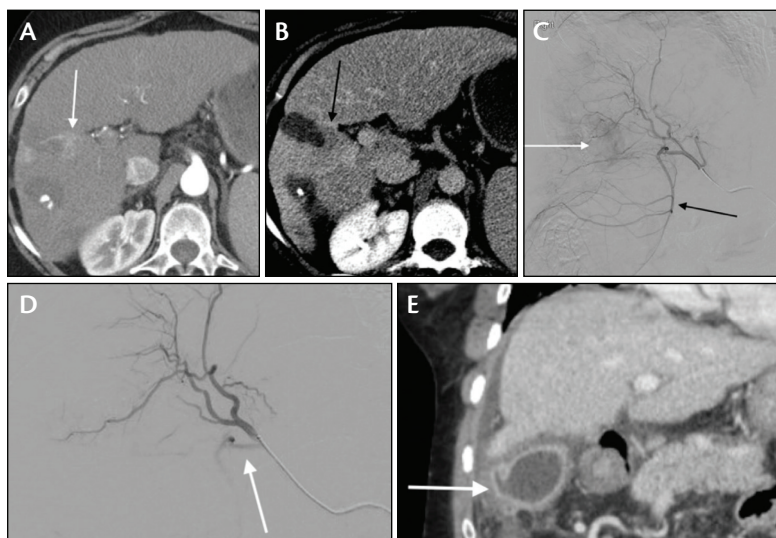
Contrast-enhanced CT demonstrated hypervascularity on arterial phase (A) and corresponding washout on a delayed phase (B) adjacent to a region of prior treatment, consistent with recurrent HCC. The hepatic arteriogram demonstrated hypervascularity characteristic of recurrent HCC. Note the large cystic artery (C, arrow). The angiogram of the right hepatic artery prior to TACE showed reflux into the cystic artery (D, arrow). CT obtained 3 weeks after TACE demonstrated gallbladder wall thickening with perforation (E, arrow).
